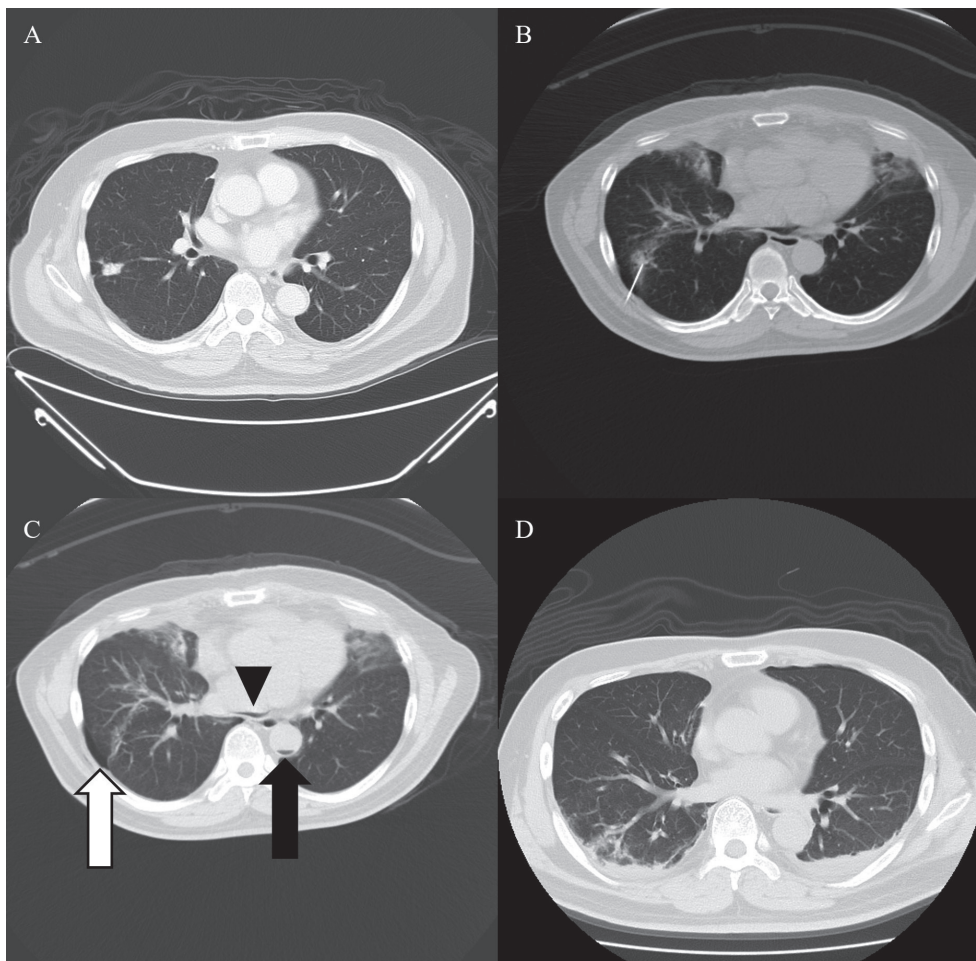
(A) A 2.0 cm nodule is noted at the right lower lobe (RLL) of the lung, with pleural traction. (B) Computed tomography (CT)-guided percutaneous lung biopsy for the RLL lesion. (C) Free air accumulation in the aorta (arrow) and pneumomediastinum (arrowhead) with right-side pneumothorax (white arrow). (D) CT scan after hyperbaric oxygen therapy (HBOT), and there was no residual free air in the cardiovascular system.
